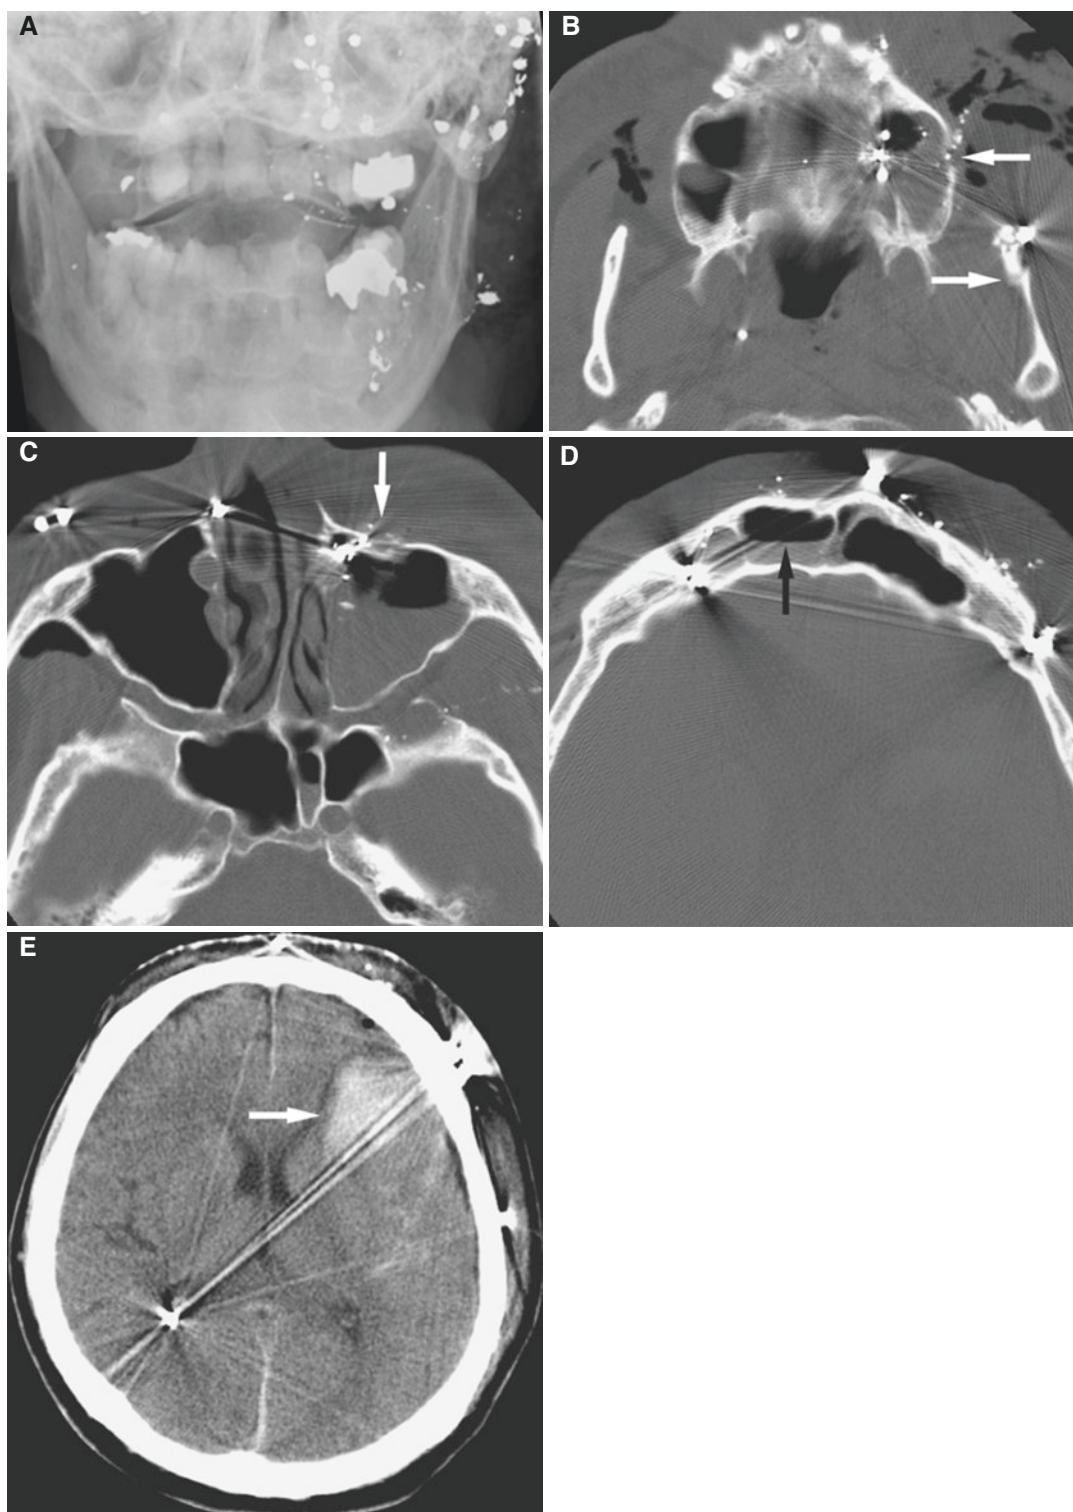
Mandibular and maxillary fractures not pronounced and without dislocations, but severe hemorrhage intracranially and in most paranasal sinuses; 60-year-old male with gunshot to the face. (A) Posteroanterior view shows numerous bullet pellets and fragments, but no obvious fractures. (B) Axial CT image shows mandibular fracture (*arrow*), maxillary sinus wall fracture (*arrow*), left maxillary sinus opacification (hemorrhage), and a number of metallic fragments and air collections, in particular in the bullet track. (C) Axial CT image shows fracture of the anterior maxillary wall (*arrow*), left maxillary sinus
